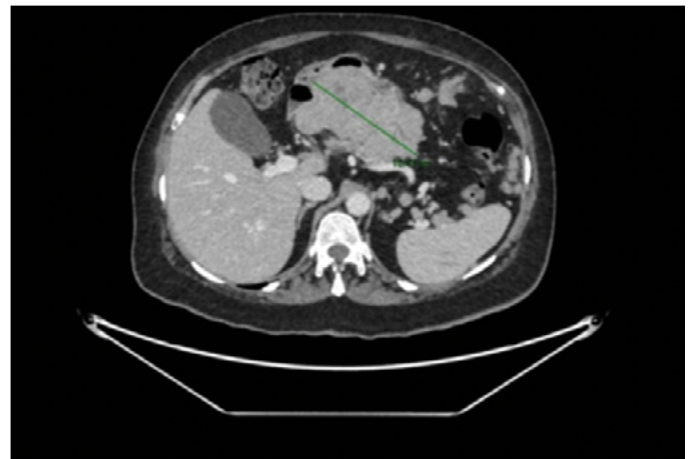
Key image from abdominal-pelvic CT scan. A 13 cm mass of probable submucosal origin is identified in the gastric wall with associated peritoneal carcinomatosis.
